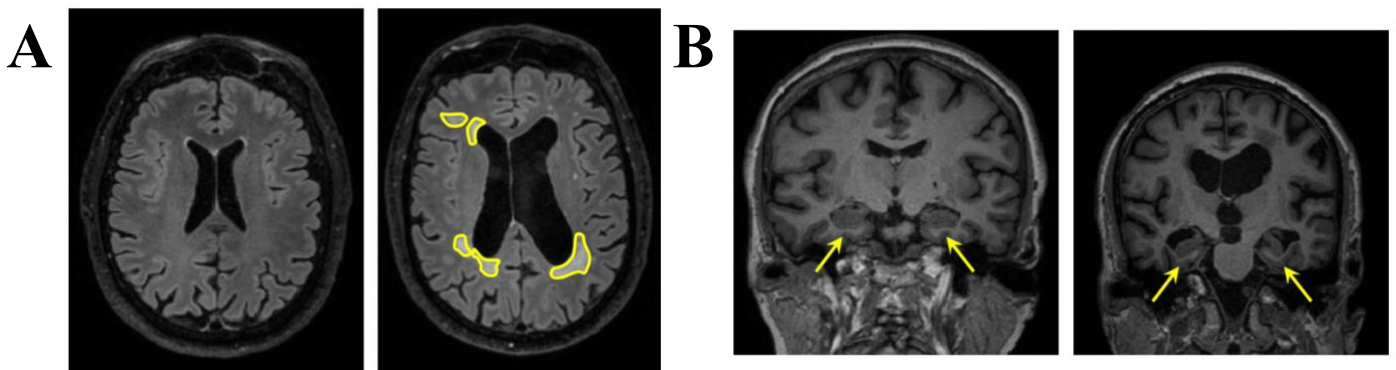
Brain MRI of individuals in the LISA study. A Examples of two participants with either small (left) or large (right) white matter hyperintensity volume. Hyperintensities are highlighted. B Hippocampus in two participants. Hippocampal atrophy in the image to the right.
